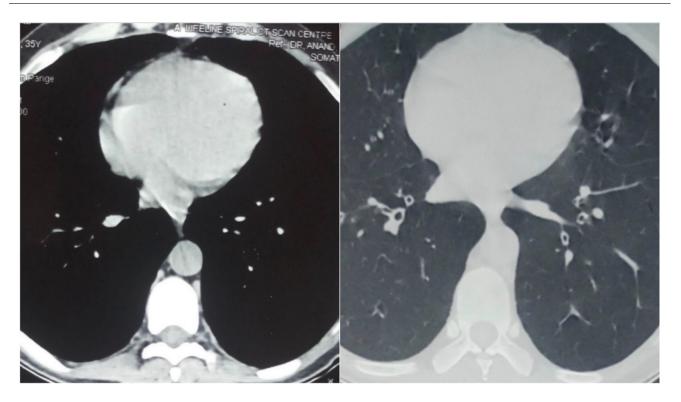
Follow-up CT scan showing complete resolution of pulmonary nodules.
